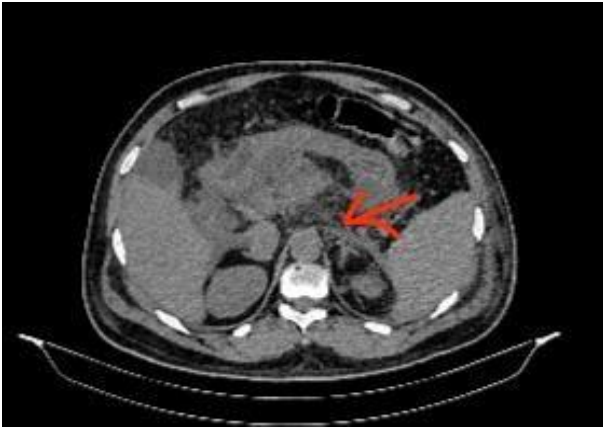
Contrast enhanced CT scan abdomen (axial view) showing areas of nonenhancement consistent with development of necrosis and thickening of left para-renal fascia (arrow mark).
